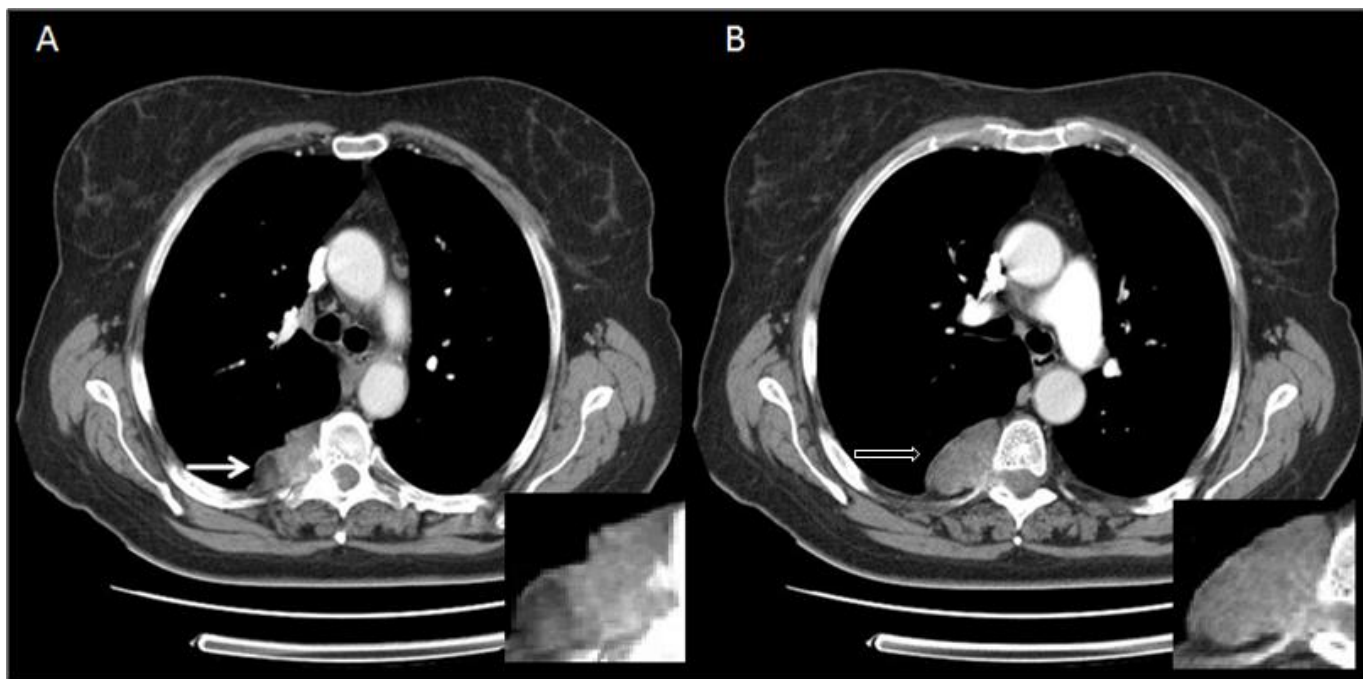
Post contrast CT appearances of an angioliipoma in a 71 year old female. Axial images from post contrast arterial phase CT scan of the chest. 3A) This demonstrates a focal fat density region within the soft tissue mass (solid white arrow). A magnification of the area of interest is demonstrated in the lower right corner. 3B) This demonstrates a heterogeneously enhancing lesion expanding the T5/6 neural foramen (hollow white arrow). A magnification of the area of interest is demonstrated in the lower right corner. (Protocol: 120 kV, 45 mAs, 4mm slice thickness, 100ml Optiray 300 contrast medium).
